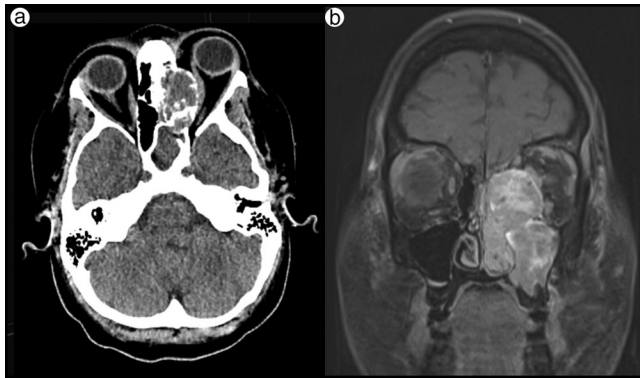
(a) CT of the head demonstrating a 6.4 cm sinonasal mass eroding into the inferonasal left orbit with displacement of the medial rectus muscle. (b) T1-weighted MRI of the face demonstrating involvement of the maxillary and ethmoid sinuses with extension through the orbit to the left anterior cranial fossa floor.
